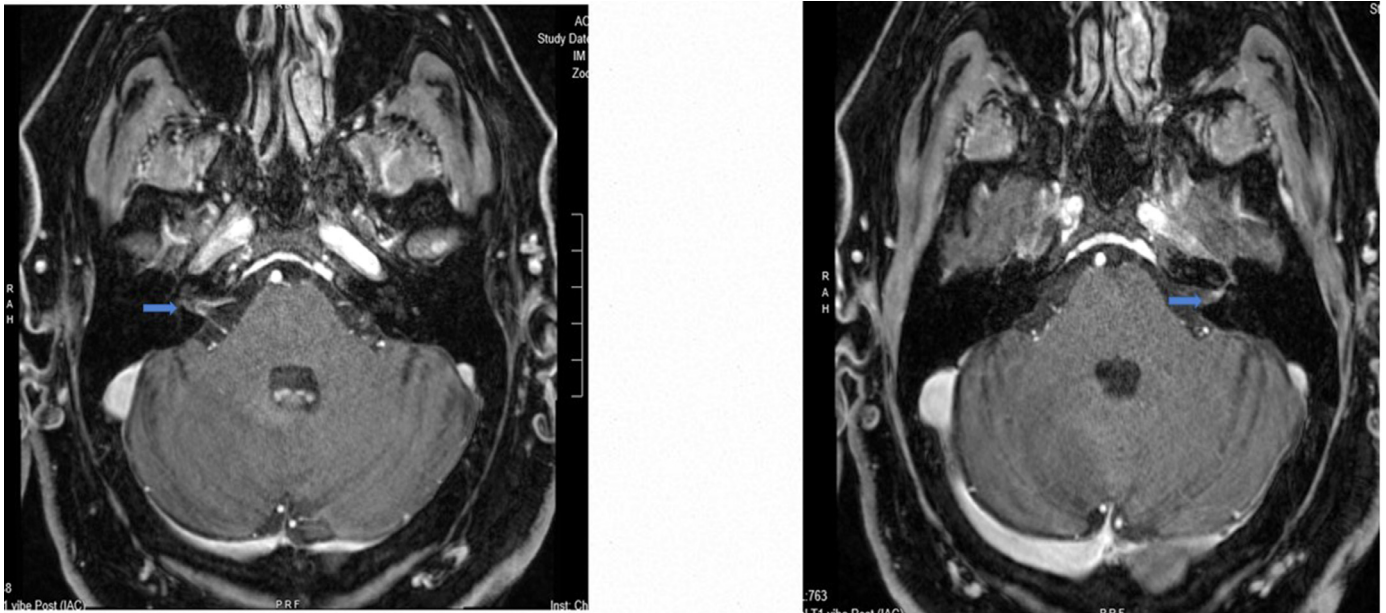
MRI axial T1 post contrast that shows the right (1a) and the left (1b) facial nerve enhancement the consent forms are only supplementary
